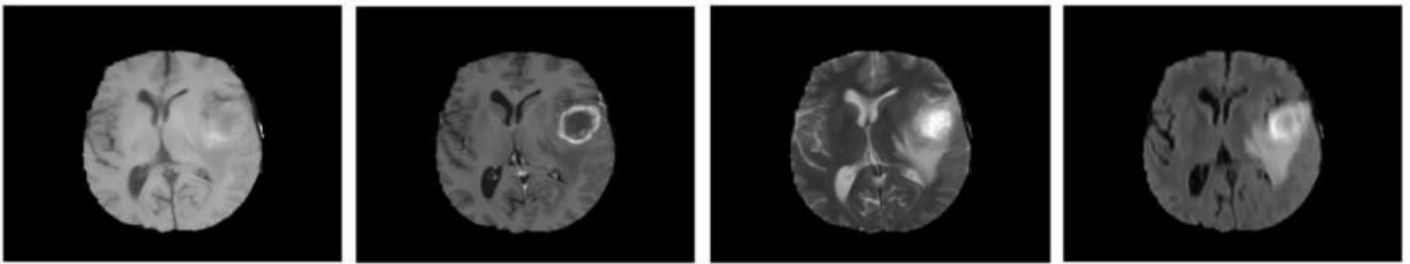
MRI Modalities showing types of glioma
